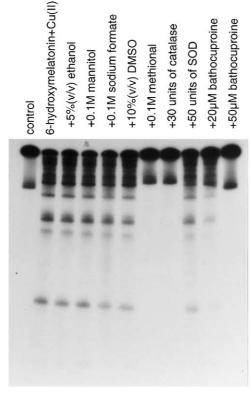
Effects of scavengers and bathocuproine on the DNA damage induced by 6-hydroxymelatonin in the presence of Cu(II). Reaction mixtures contained the  $^{32}\text{P-5'-end-labeled}$  443-base-pair DNA fragment, 20  $\mu\text{M}$ /base of calf thymus DNA, 20  $\mu\text{M}$  6-hydroxymelatonin and 20  $\mu\text{M}$  CuCl $_2$  in 200  $\mu\text{L}$  of 10 mM sodium phosphate buffer (pH 7.8) containing 5  $\mu\text{M}$  DTPA. Reaction mixtures were incubated for 2 h at 37 °C. DNA fragments were treated with 1 M piperidine for 20 min at 90 °C, then electrophoresed on an 8% polyacrylamide/8 M urea gel. The autoradiogram was visualized by exposing an X-ray film to the gel.
